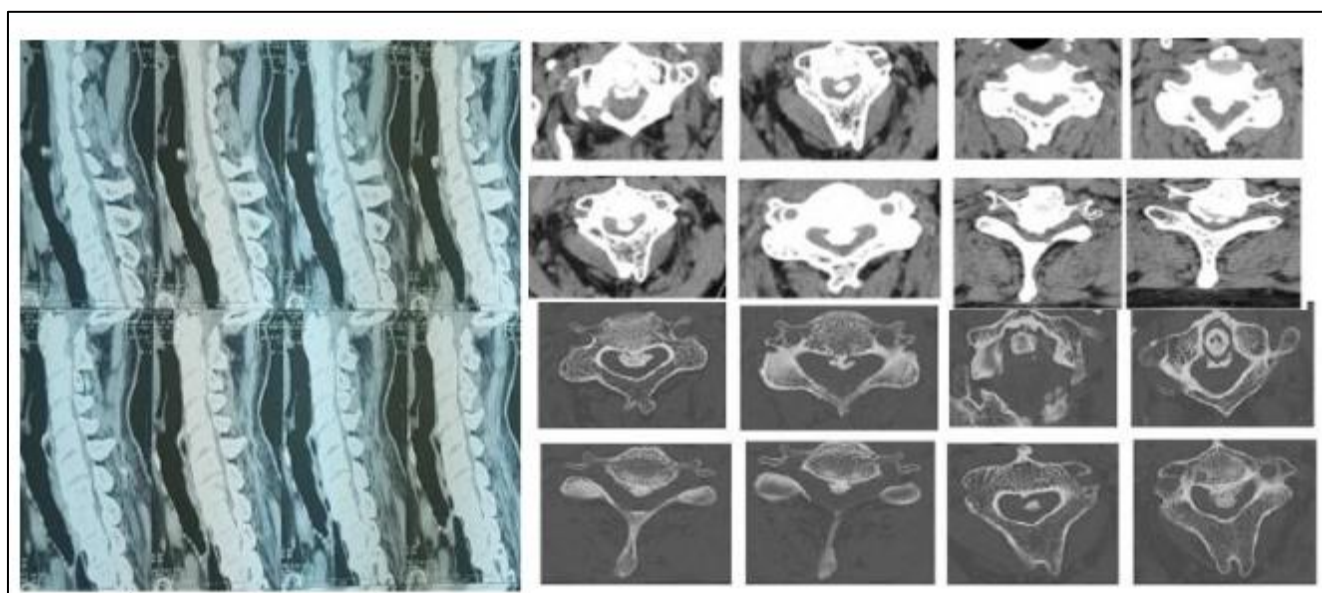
Cervical spine CT scan. Sagittal parenchymal window images show cervical canal narrowing at C2–C4 and C5–C7 levels due to an intracanalicular calcified Axial images demonstrate extensive OPLL leading to significant spinal canal stenosis lesion . the cervical lordosis is relatively preserved
